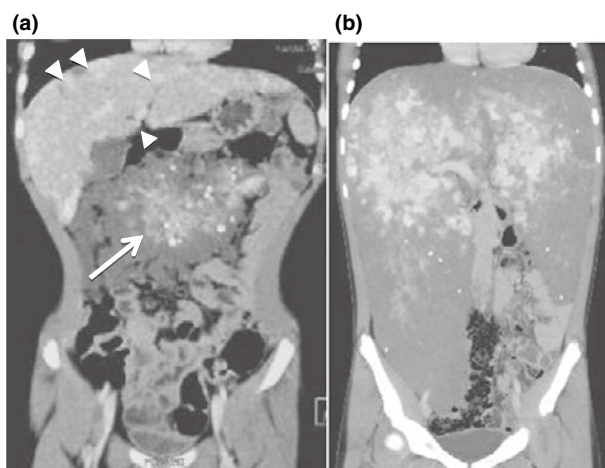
(a) Enhanced abdominal CT at first visit (aged seven) shows a mass with calcification in the transverse colon (arrow) and multiple enhancing liver lesions (arrowheads). (b) Seven yr after (aged 14), the liver extends into the pelvic cavity. Whole liver volume was 7142 mL, as determined by CT volumetric analysis.
